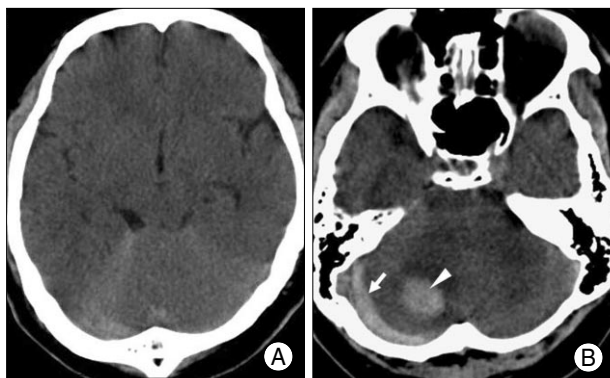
Computed tomography at admission showing a subarachnoid hemorrhage under the falctentorium (A), subdural (arrow) and subcortical (arrowhead) hematoma in the right cerebellum (B).
